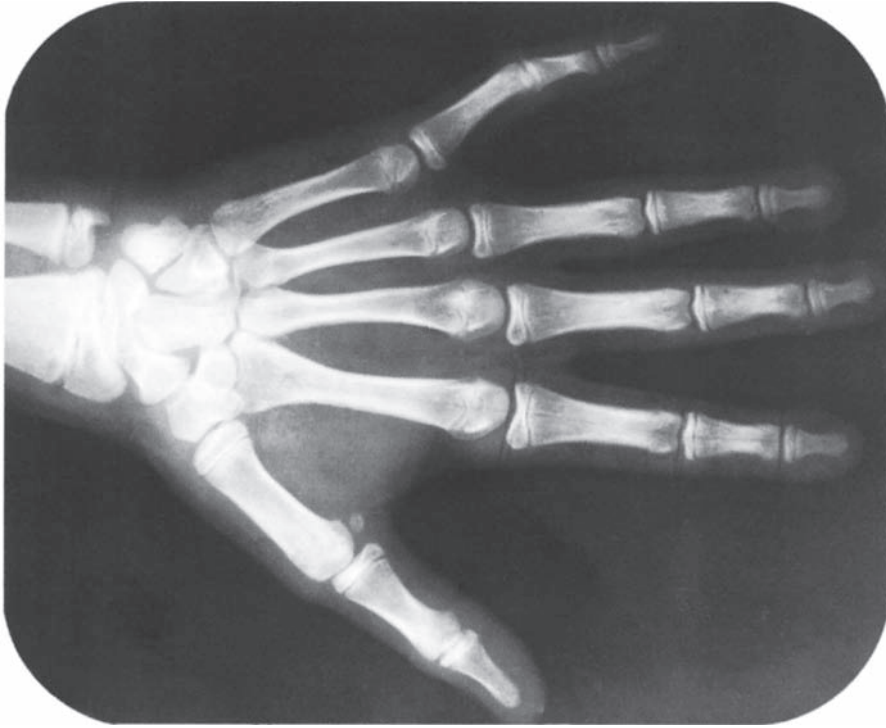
Hand-wrist X-ray of a 14-year-old.
